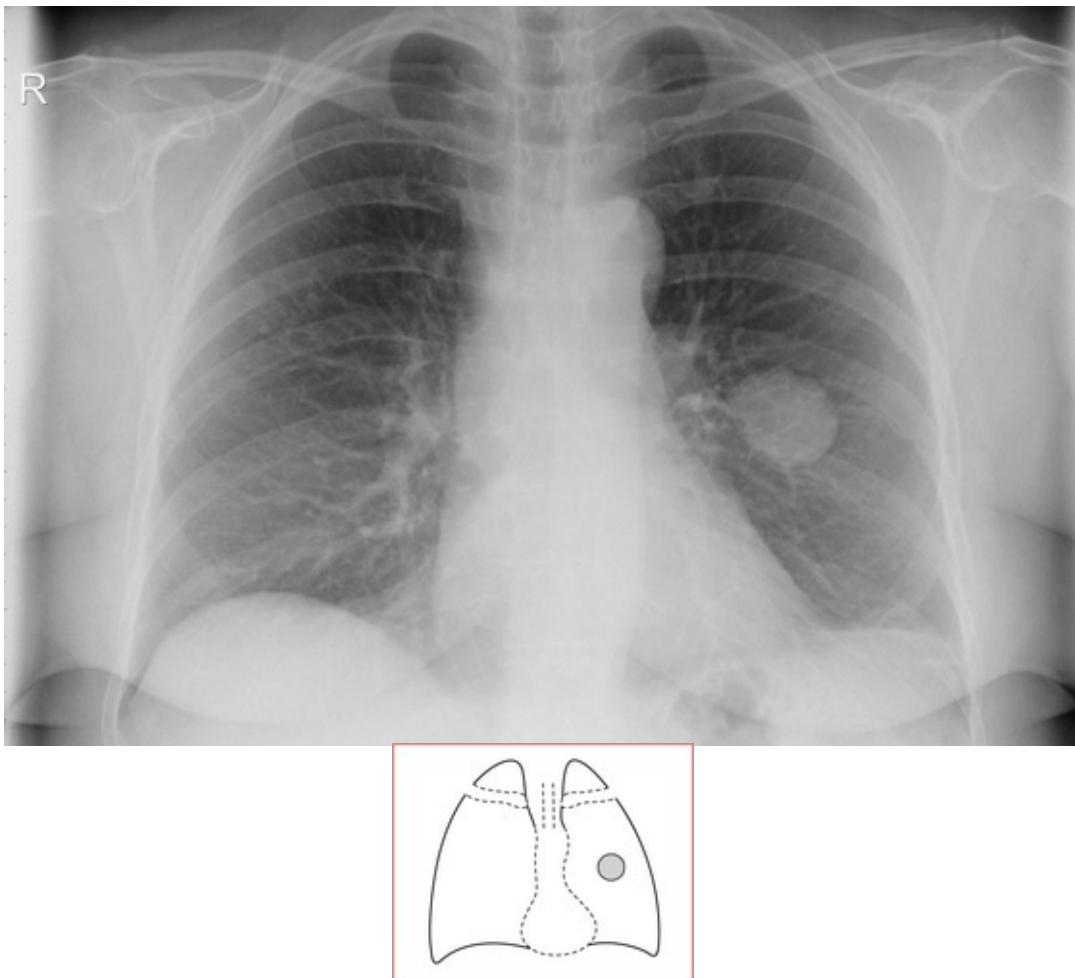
There is a 3 cm round nodule in the left mid zone. This would need to be investigated as it may represent a small tumour. The nodule could be biopsied percutaneously under CT guidance.
